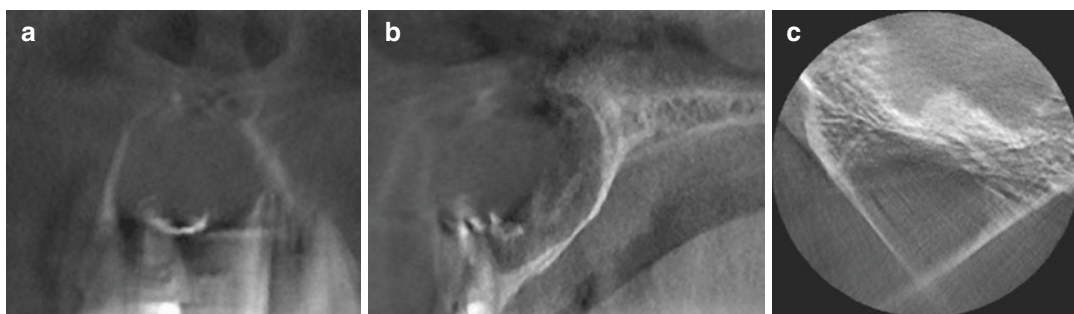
Reformatted panoramic (a), coronal (b), and sagittal (c) CBCT images showing generalized unsharpness indicating continuous patient motion during the scan
